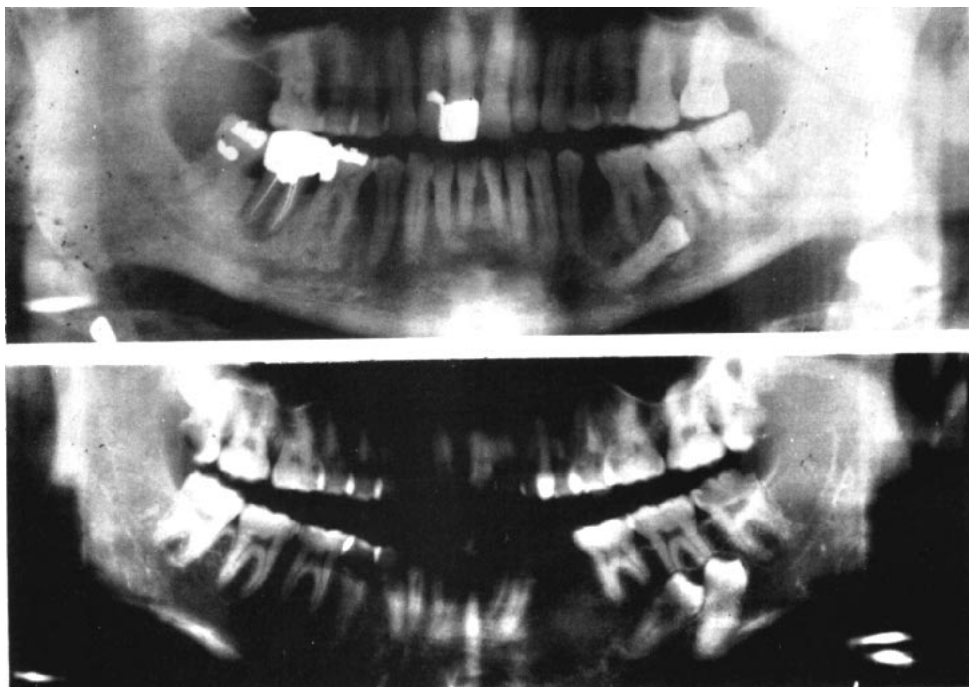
(a) Panoramic radiograph showing distal migration of second bicuspid below the first molar, with resorption on the distal root of the molar. (b) Panoramic radiograph showing distal migration of both left bicuspids below first and second molars, with molar root resorption.
